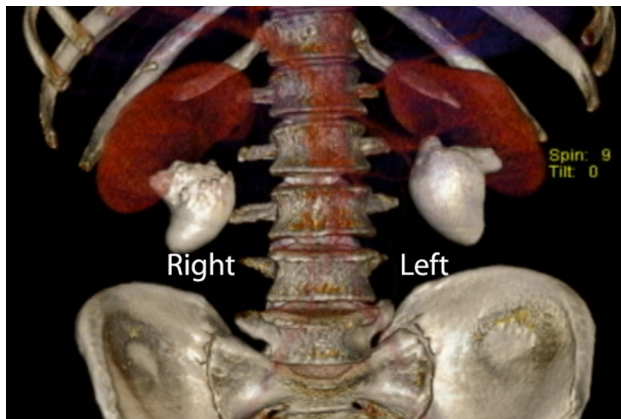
Reconstructed image of computed tomography showing large kidney stones on both sides, occupying predominantly extrarenal pelvis and preserved kidney parenchyma
